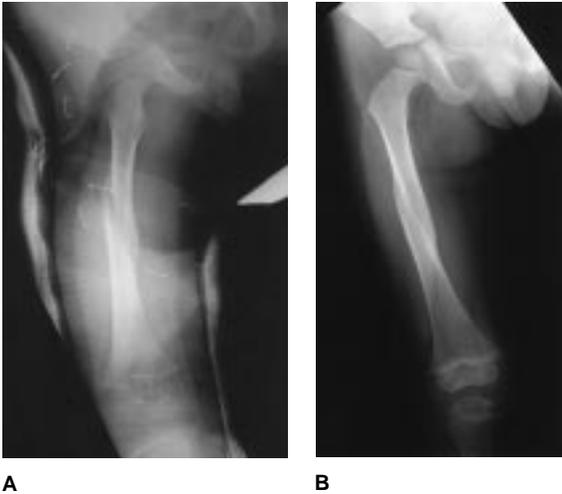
A, Radiograph obtained 3 weeks after immediate spica casting of an isolated stable femoral-shaft fracture in a 2-year-old child. B, Three months after injury, the fracture has healed in good position.
